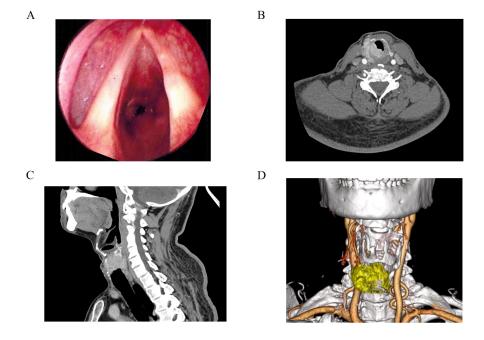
Preoperative laryngoscopy and CT scan findings. (A: A tumor located on the inner aspect of the trachea. B, C: Expansile lesion involving the right side of the cricoid cartilage and the first to third tracheal rings. D: 3D reconstruction of the tumor and cricoid cartilage, with the tumor depicted in yellow.)
